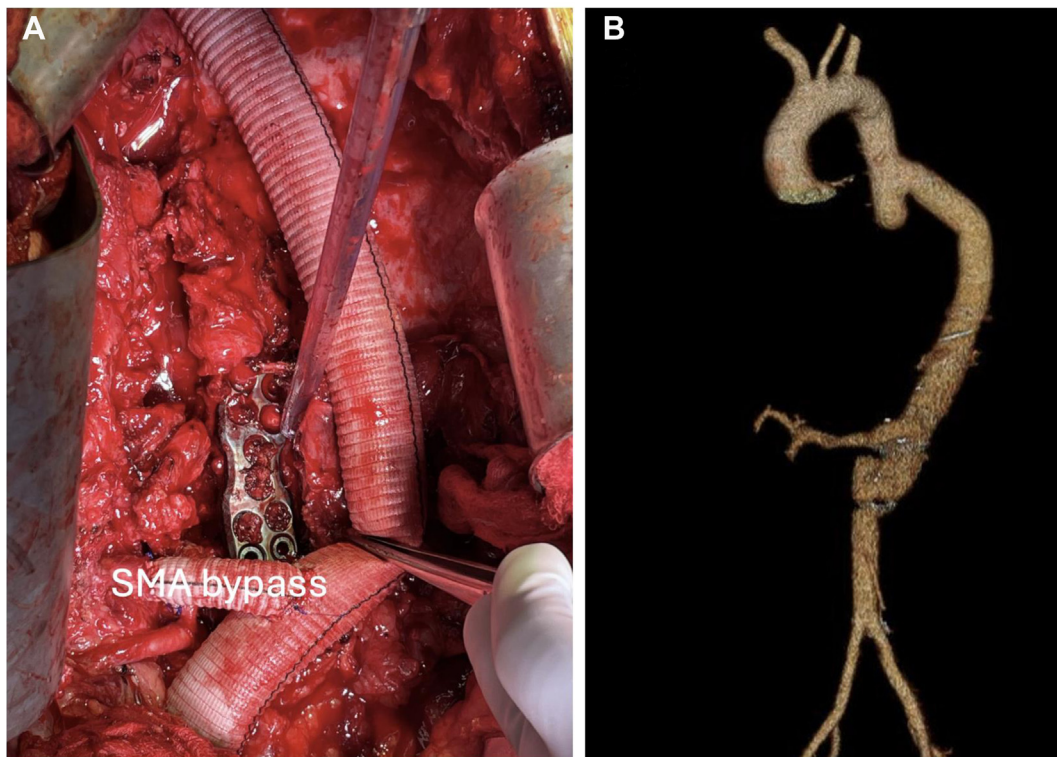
(A) Intraoperative photograph of eroded spinal plate and the aortic tube graft and superior mesenteric artery (SMA) bypass. (B) Computed tomography three-dimensional rendering of postoperative anatomy.
